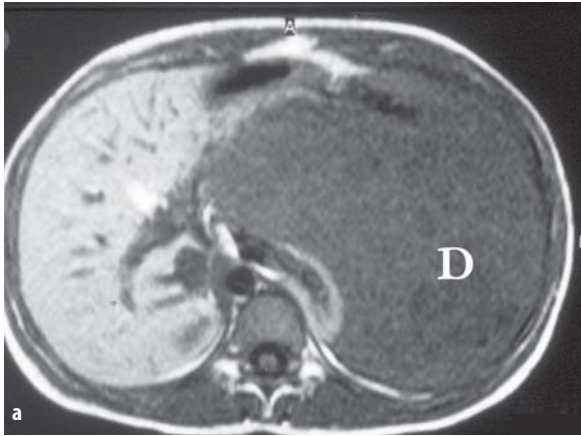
Preoperative magnetic resonance imaging (MRI) scan. *D*, desmoid tumour
